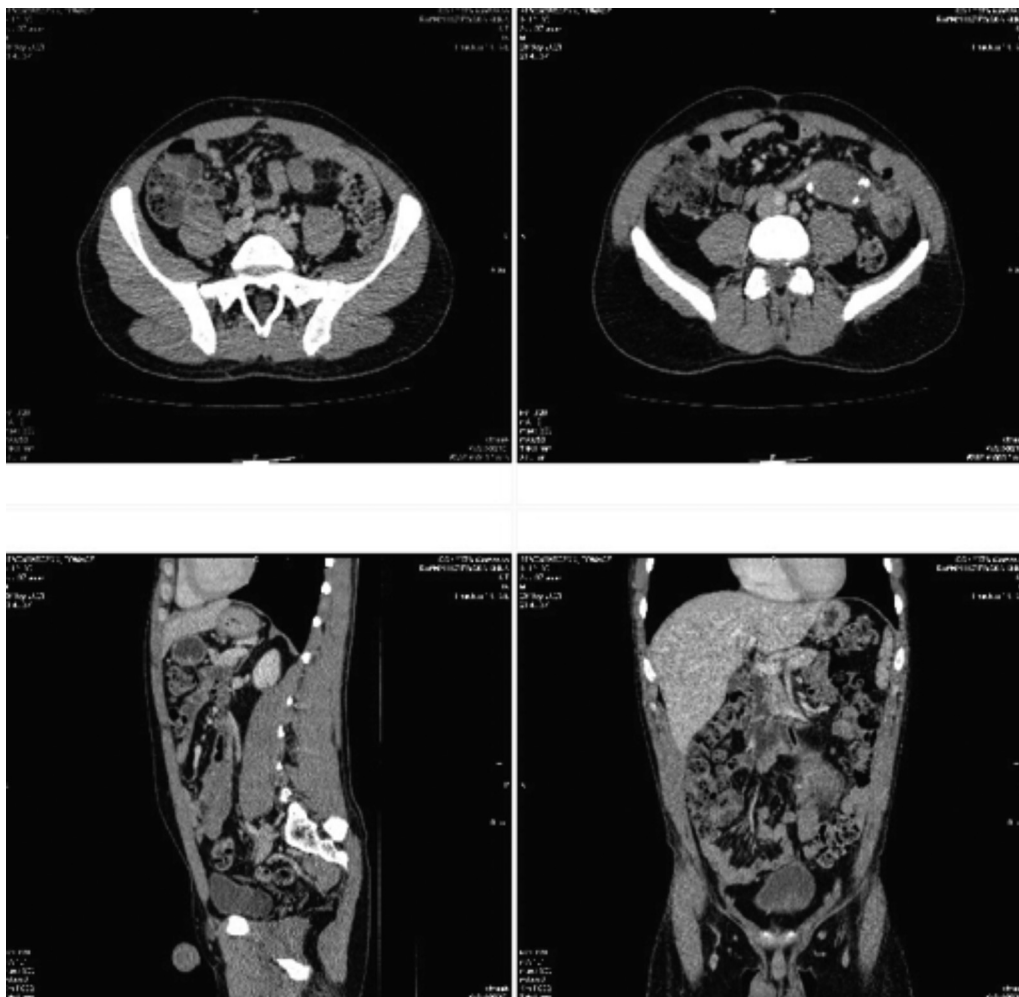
Case 17. Abdominal computed tomography scan of the sagittal section. The computed tomography scan revealed that the transplanted pancreas was enlarged, was heterogeneous, had edema, had arterial vascularization of the graft from the right iliac artery only in the initial segment, and had venous outflow only slightly visible in the proximal part
